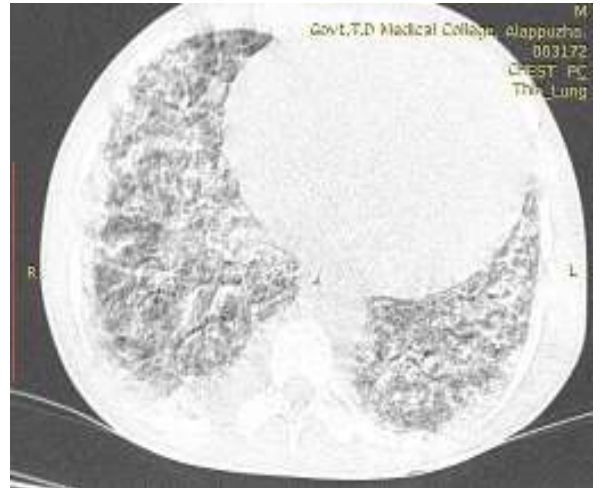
Lung window- HRCT
